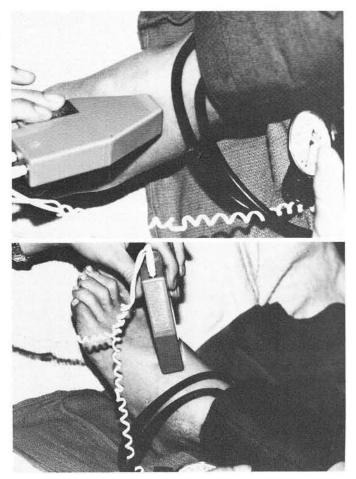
Ankle-arm indices can be obtained by recording systolic blood pressures of brachial artery and dorsalis pedis artery using Doppler and pneumatic blood pressure cuff.
